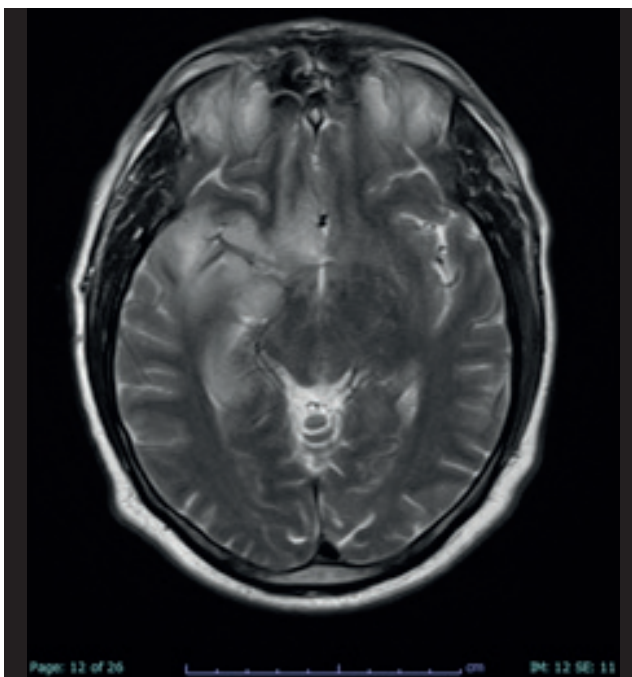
Patient cranial MRI axial T2W image showing hyperintensity at right temporal lobe, due to cytotoxic edema
